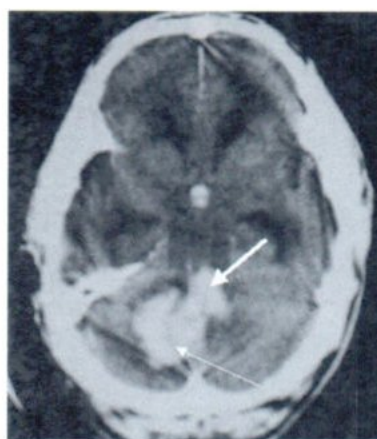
NC.CT. showed cerebellar hematoma Rt. side showing by small, long white arrow. There was also hematoma filling into the 4th ventricle, pointed by short, thick white arrow.
